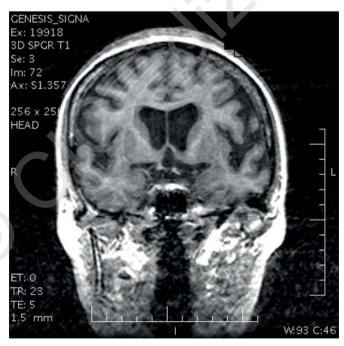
MRI performed in 2006 showing mild frontal and temporal cortical atrophy.
